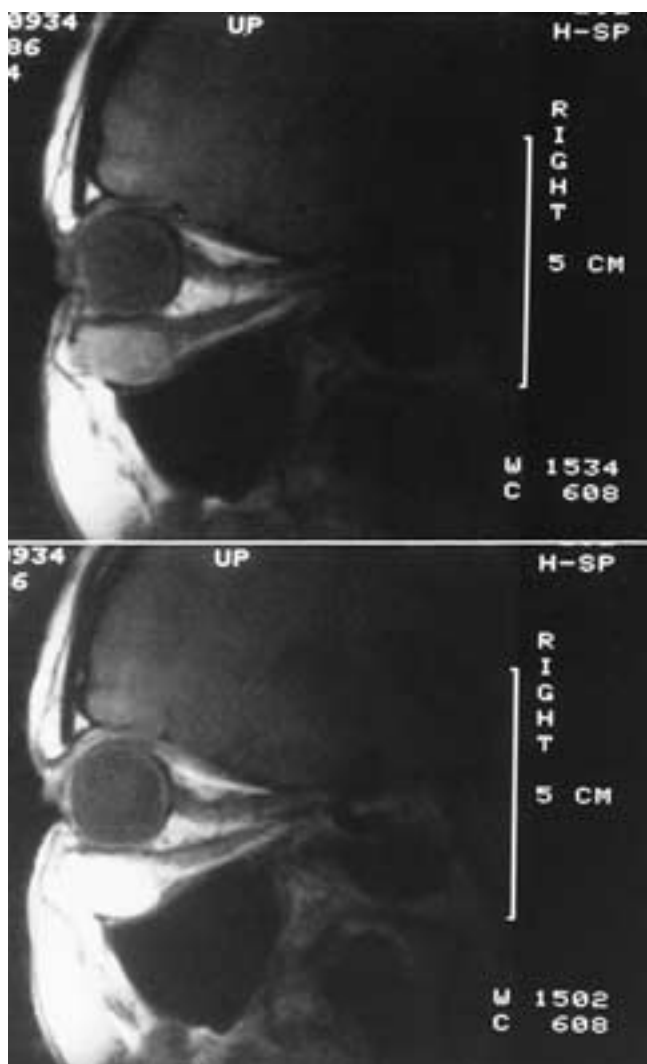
Orbital hemangioma. Sagittal MR images obtained without (*top*) and with (*bottom*) intravenous Gd-DTPA show a hemangioma in the anterior floor of the orbit. (Courtesy of Dr. August F. Markl.)
